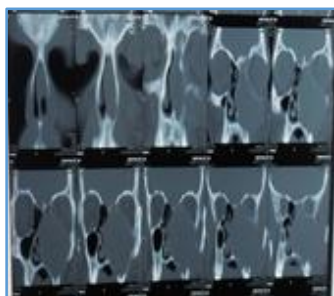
CT Scan: homogenous soft tissue density in the left maxillary sinus
